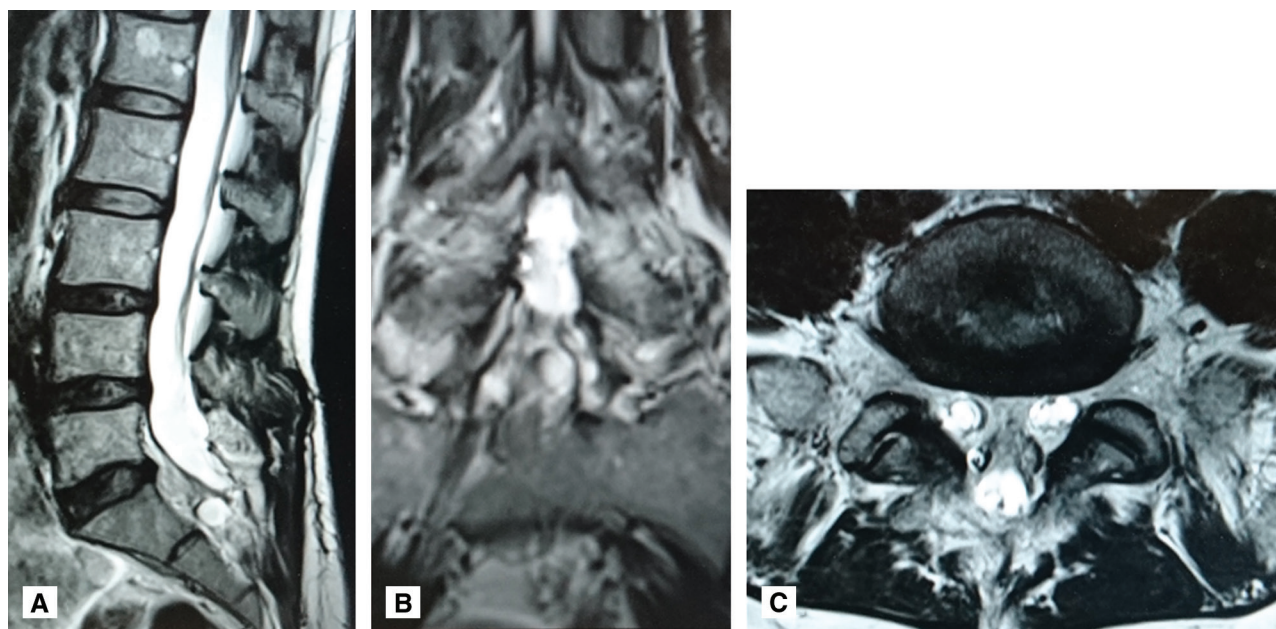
MRI of lumbosacral spine 2 years after surgery: (A) sagittal view of T2WI, (B) coronal view of T2WI, (C) axial view of T2WI. MRI shows complete resection of ET and no recurrence of Tarlov cyst. ET: epidermoid tumor, MRI: magnetic resonance imaging, T2WI: T2-weighted image.
